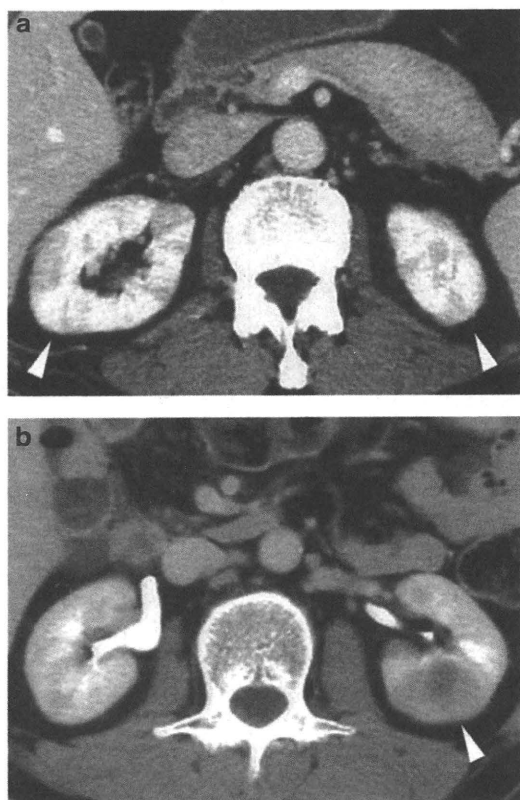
Contrast-enhanced renal CT findings in patients with IgG4-related nephropathy. (a) Multiple wedge-shaped low-attenuation lesions in both renal cortices are evident (arrows, patient 3); (b) A tumor-like less-enhanced mass (arrow) is evident in the left kidney (patient 8). CT, computed tomography.
